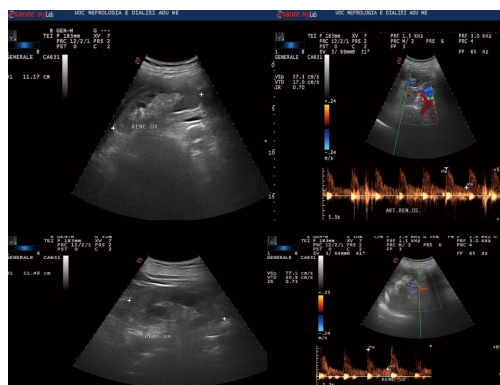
Renal ultrasound.
